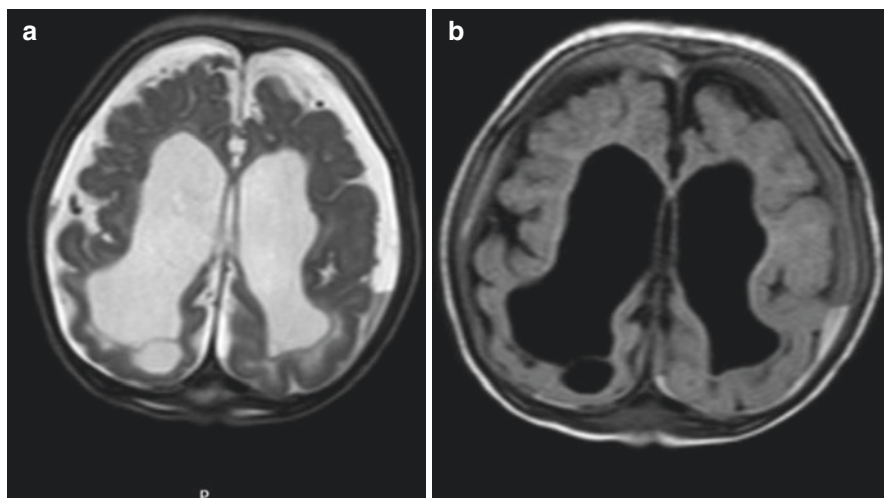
A 2-year-old patient with a metabolic disease. The T2-weighted magnetic resonance imaging (MRI) scan (a) showed a CSDH overlying both cerebral hemispheres as hyperintense and isointense to cerebrospinal fluid (CSF); however, on the FLAIR image (b), the signal intensity is higher than CSF, indicating a different protein content
